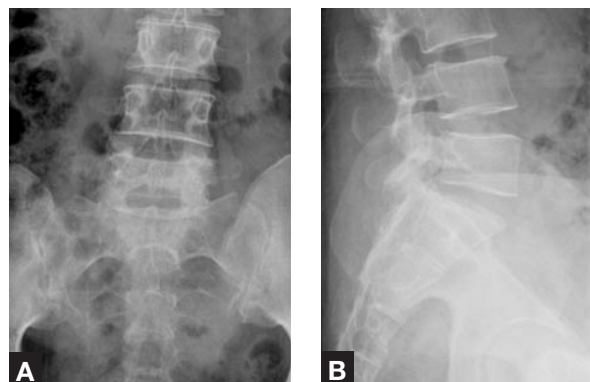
Anteroposterior (A) and lateral (B) plain radiographs of lumbosacral spine are unremarkable.
